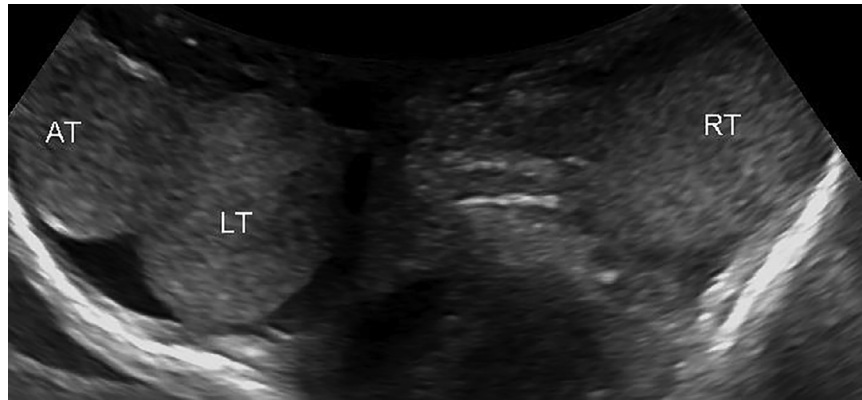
Testicular gray scale sonography with 2 similar echotexture testis in the left hemiscrotum and 1 testis in the right hemiscrotum.
